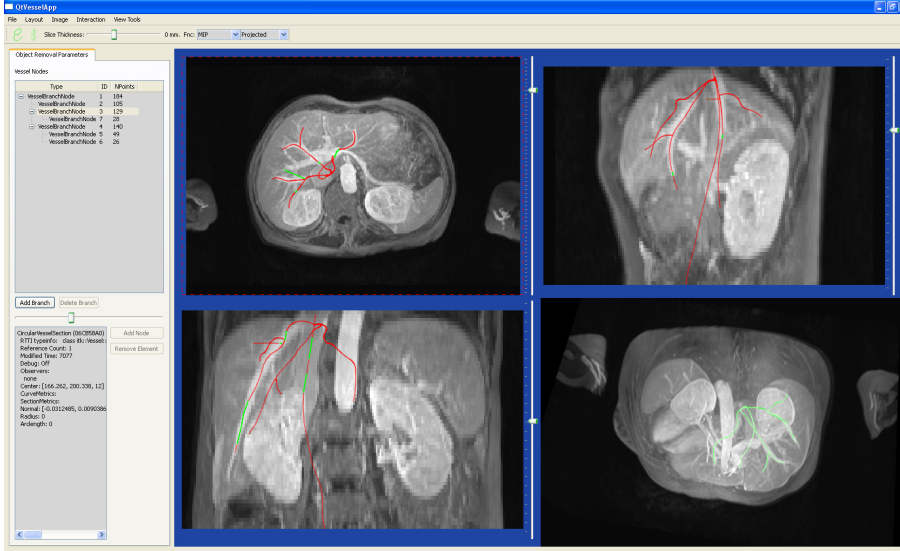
Screen capture of the visualization given by the modeling application under development. Lines correspond to vessel centerlines created interactively by a user over a liver CTA.
